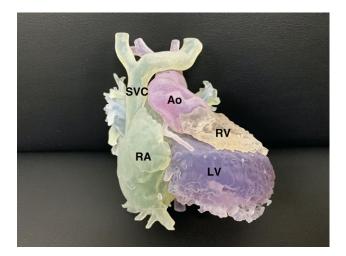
A 3D printed blood pool model of DILV which was created using CT data obtained from a 43-month-old patient. 3D = three-dimensional; Ao = aorta; CT = computed tomography; DILV = double inlet left ventricle; LV = left ventricle; RA = right atrium; RV = right ventricle; SVC = superior caval vein.
